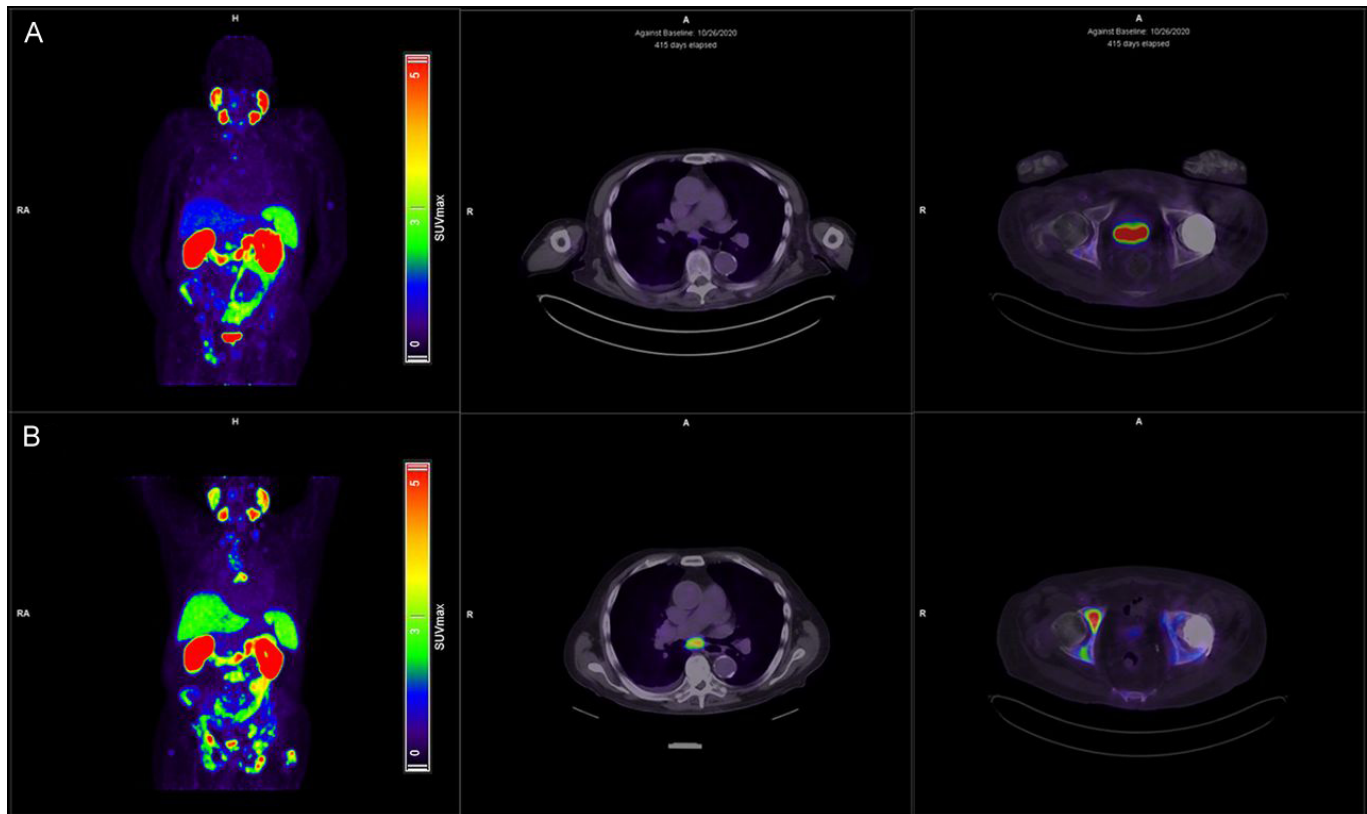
PSMA PET imaging before (B) and after (A) 2 sessions of ^{225}Ac -DOTA-J591 in a patient with metastatic castration-resistant prostate cancer. Post-treatment maximum-intensity-projection images show considerable decrease in disease burden, especially in subcarinal lymph node (column 2) and osseous lesions (column 3) (adapted from literature [20]).
